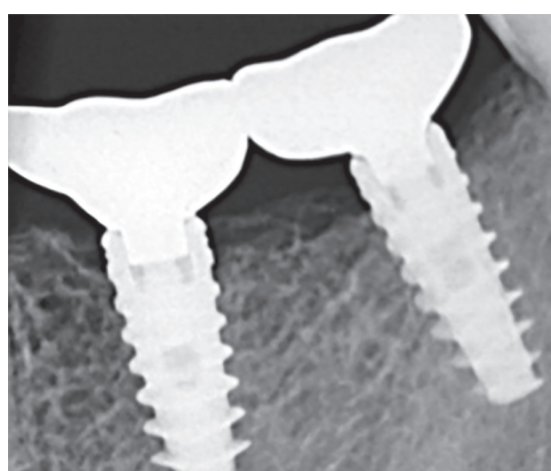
One-year follow-up radiograph
